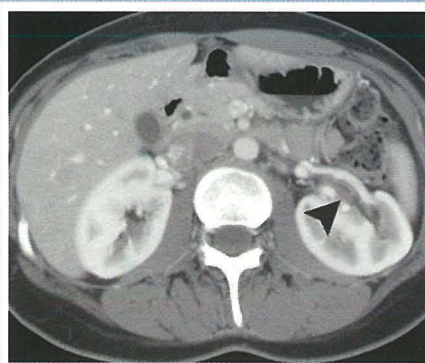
CT scan showing unilateral pyelitis in a patient with suspected acute bacterial pyelonephritis
